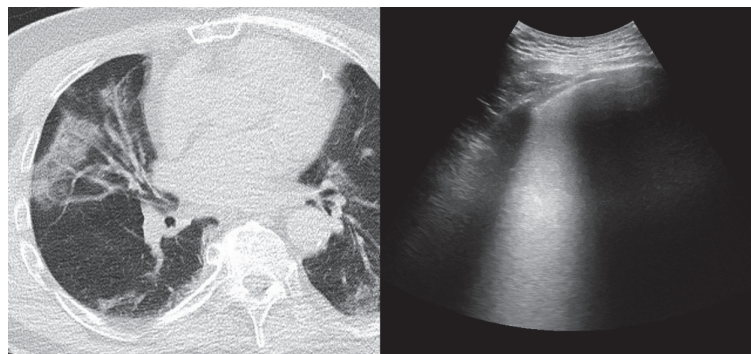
Left panel: CT scan demonstrating bilateral GGO with tendency of consolidation. Right panel: LUS demonstrating thickening of the pleural line and intercostal predominantly coalescent B-lines or B2 pattern.
